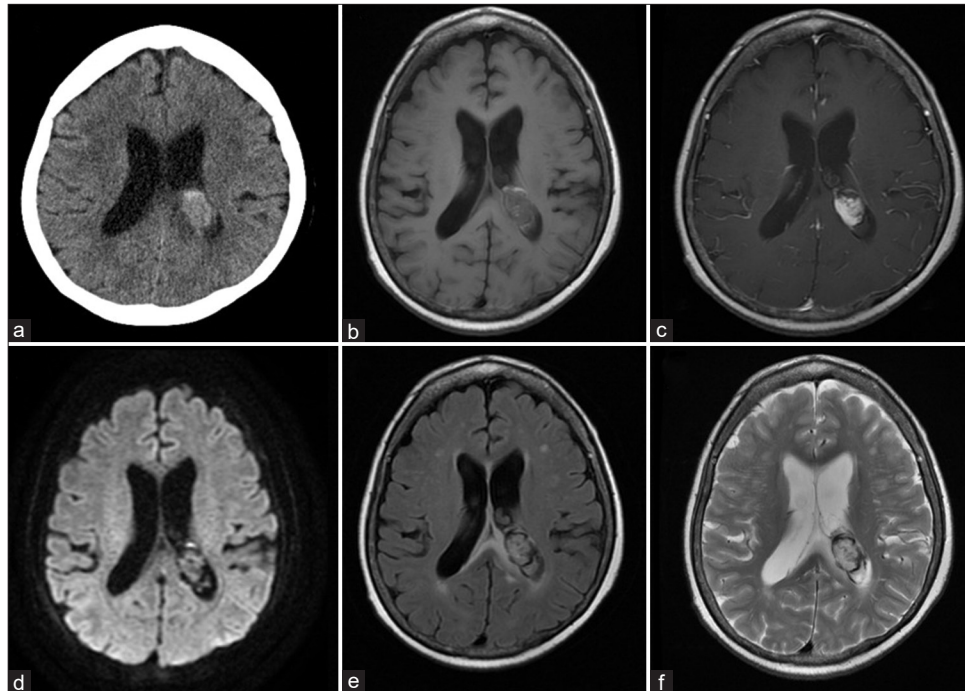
Preoperative computed tomography (CT) and magnetic resonance images. (a). CT images revealed a mass lesion with bleeding in the posterior horn of the left ventricle to the trigone part. (b) T1-weighted, (c) enhanced T1-weighted, (d) diffusion-weighted imaging, (e) fluid-attenuated inversion recovery, and (f) T2-weighted images.
